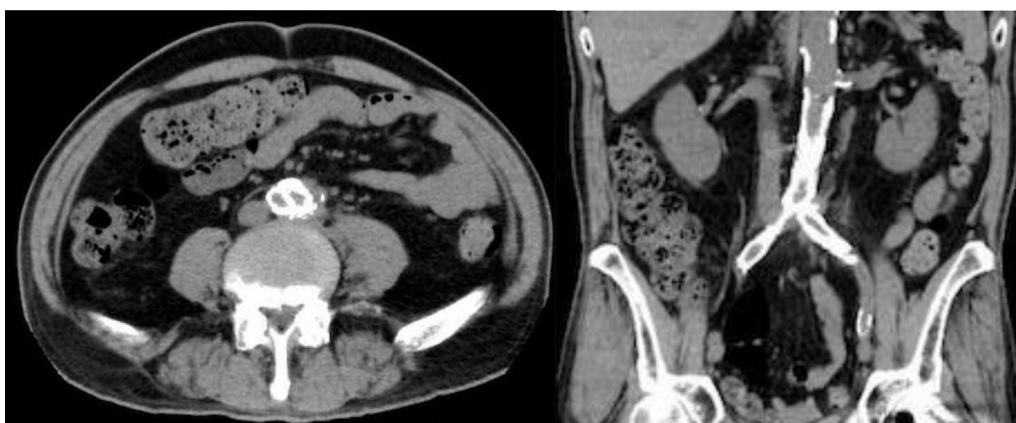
Preoperative computed tomography (CT) angiography shows an encapsulated low-density area around the terminal aorta. Arrows indicate the pseudoaneurysm.
